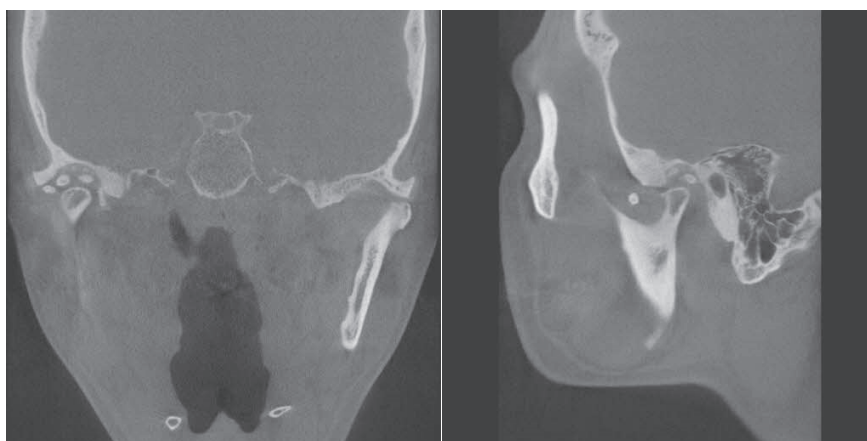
Coronal and sagittal view of computed tomography. Right glenoid fossa erosion was present compared to the opposite condyle. The right condylar head shows a loss of the normal smooth cortical margin with evidence of mixed sclerosis and radiolucency which shows cortical irregularity, and possible erosion is noted on the superior aspect of the condyle. The joint space is narrowed, suggesting possible degenerative changes.
